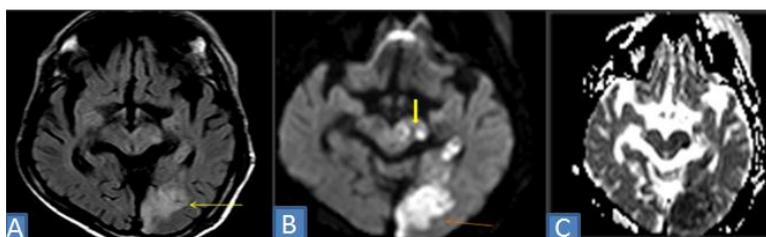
Acute non hemorrhagic infarct in left occipital lobe (PCA territory) appearing hyperintense on Axial FLAIR (A), showing restricted diffusion on DWI (B) with low ADC values(C)
